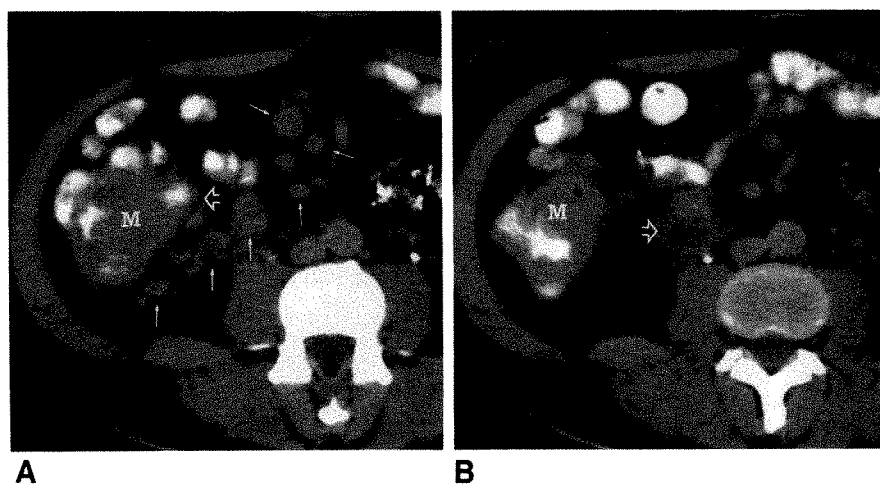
CT scans show cecal mass combined with caseation necrosis of mesenteric lymph nodes in patient who does not have AIDS.
